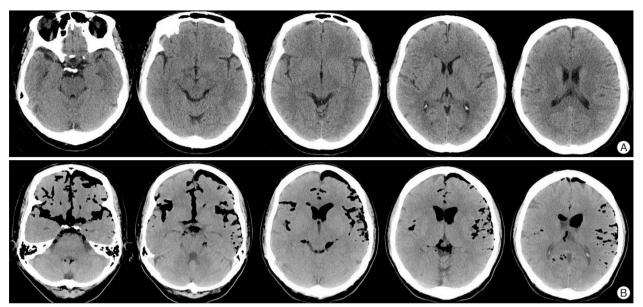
Brain CT images of the patient, obtained at the local clinic the day before (A) and at our hospital on admission day (B). Newly appeared diffuse and severe pneumocephalus in the subarachnoid spaces and ventricles are shown on the (B).
